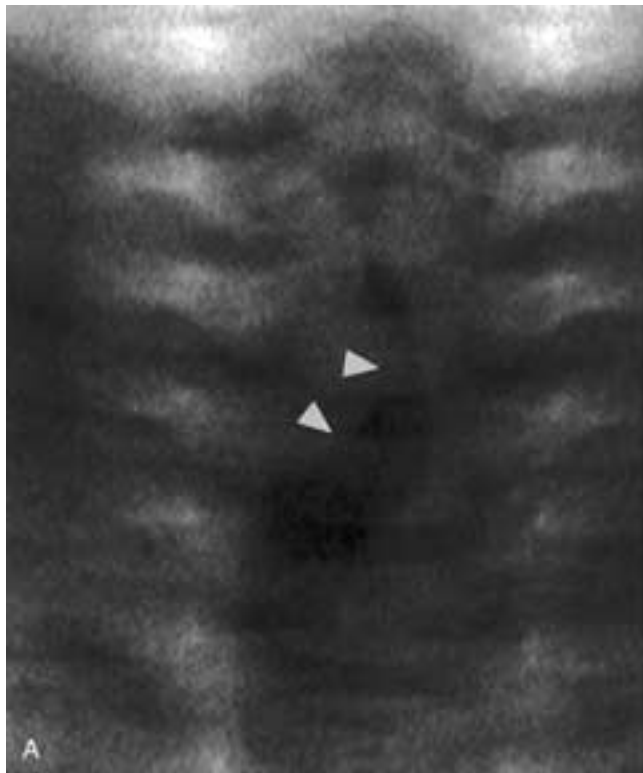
Subglottic hemangioma in a 6-week-old boy with stridor. A, Frontal plain film shows indentation of the trachea (*arrowheads*) by a right subglottic mass. An axial contrast-enhanced CT scan was obtained several weeks later. B, An image at the level of the thyroid gland shows interval enlargement due to proliferation of the intensely enhancing right subglottic hemangioma, which now fills the trachea (*arrow*). The patient had a tracheostomy tube in place.
